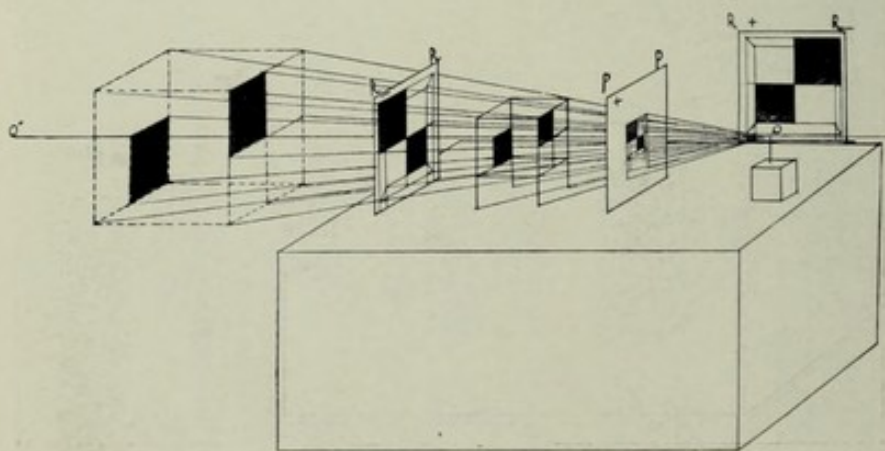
Graphic and radiographic projection.*
